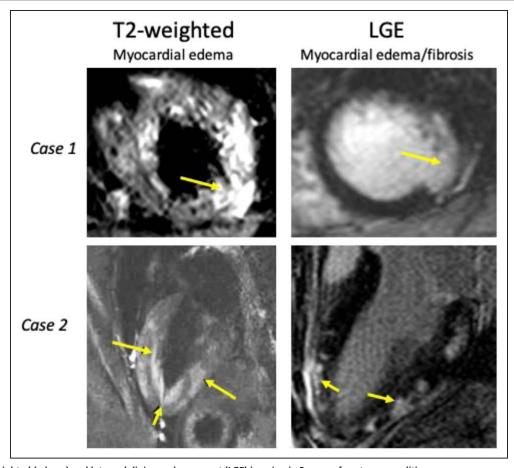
T2-weighted (edema) and late gadolinium enhancement (LGE) imaging in 2 cases of acute myocarditis.
